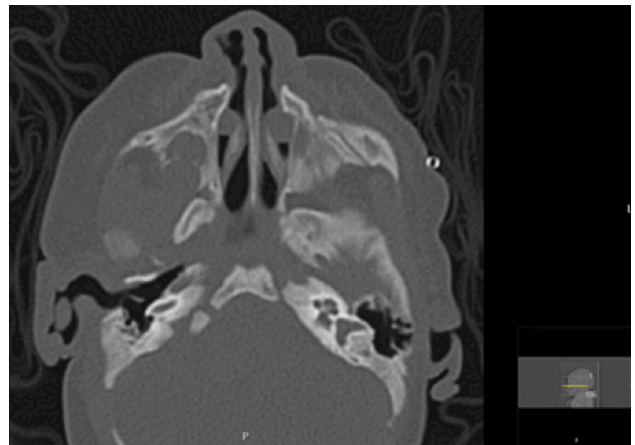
Axial image of computed tomography of the sinuses showing enlargement of the nasolacrimal channels, resulting in bilateral reduction of nasal cavity permeability
